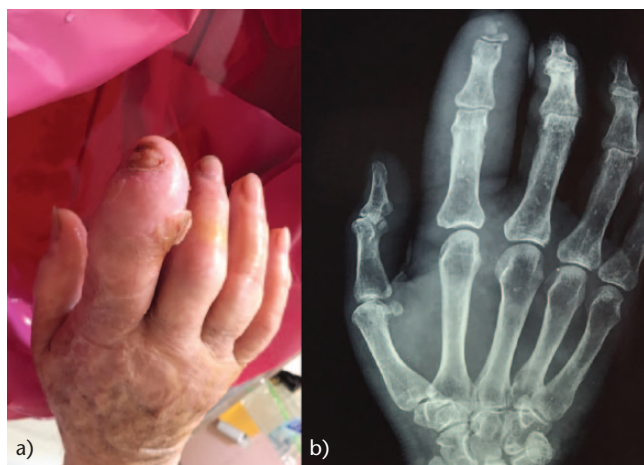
(a) Clinical photograph and (b) radiograph of the hand show osteomyelitis of the distal phalanx of the index in a patient with diabetes mellitus.
